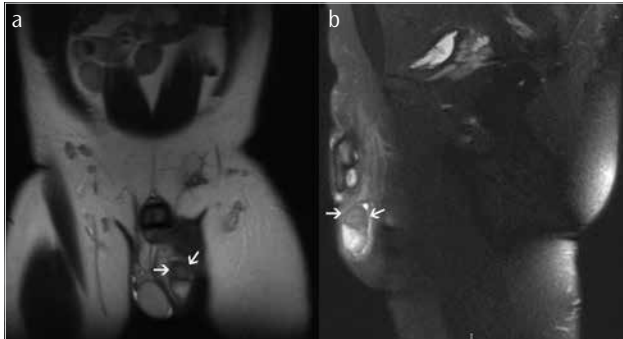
a, b. Magnetic resonance image of the lesion
